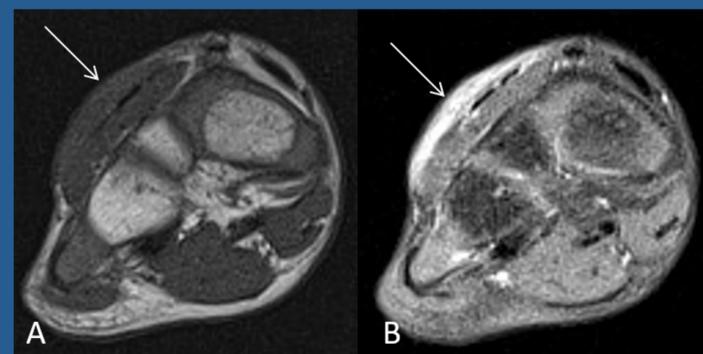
Companion case No. 1. A five-year old boy with a palpable lump. An ill-defined subcutaneous mass of the dorsal forefoot next to extensor tendons of fingers (arrow) is isointense to muscle on T1-weighted coronal image (A) and hyperintense on coronal PDFS image (B).
